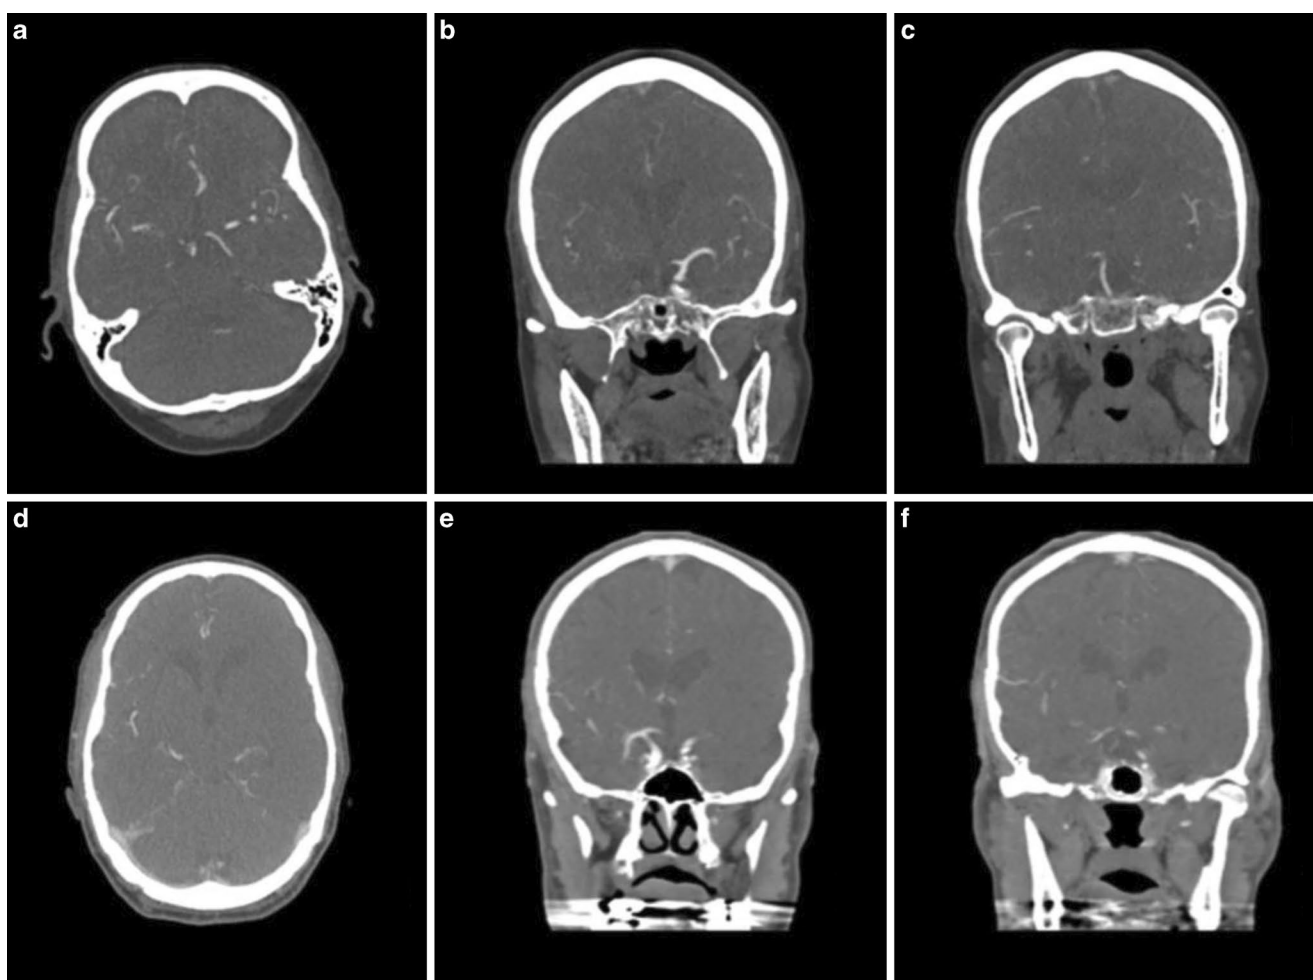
CT-A scan and survey of collateral scores. a–c CT-A scan of a patient with occlusion of right internal carotid artery (ICA), d–f CT-A scan of a patient with occlusion of left middle cerebral artery (M1); a, d 2.25 mm axial maximum intensity projection; b, c, e, f 1 mm coronal maximum intensity projection. a–c mTan Score was 2 (more than 50% of affected MCA territory opacified in comparison to non-affected MCA territory), Miteff Score was 3 (main vessel branches and collaterals are reconstituted distal to the Sylvian fissure), Moas Score was 3 (MCA territory of affected and non-affected hemisphere are opacified similarly), Opercular Index Score Ratio was 1 (favorable OISr). d–f mTan Score was 1 (less than 50% of affected MCA territory opacified in comparison to non-affected MCA territory), Miteff Score was 1 (vessels and collaterals after occlusion are not reconstituted up to the Sylvian fissure), Maas Score was 1 (there is no vessel opacification in affected MCA territory), Opercular Index Score Ratio was >2 (poor OISr)
